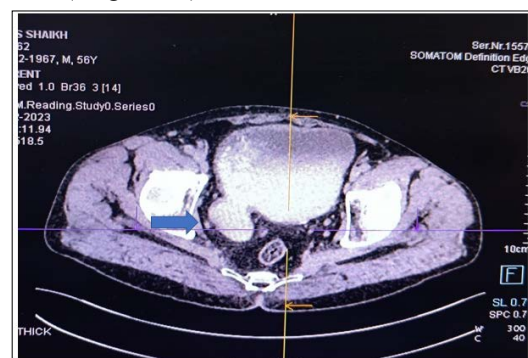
Axial section of CT urography (Excretory phase) showing right ureter draining into right hutch diverticulum
